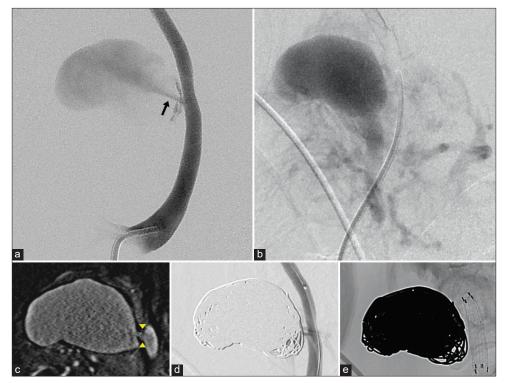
Angiography of the right internal carotid artery (a,b) demonstrates in the early arterial phase (a) a contrast collection that fills the middle portion of the tumor with a jet flow (arrow). During the late arterial phase (b), multiple blood vessels originate from the 3.5 cm contrast collection. Cone Beam CT reconstruction with contrast injection in the right internal carotid artery (c) demonstrates filling of the intratumoral pseudoaneurysm (arrowhead). Post-procedural angiography (d,e) shows near-complete resolution of the pseudoaneurysm and a 5 mm x 50 mm Viabahn covered stent (W.L. Gore and Associates, Newark, DE, USA) deployed in the cervical internal carotid artery.
